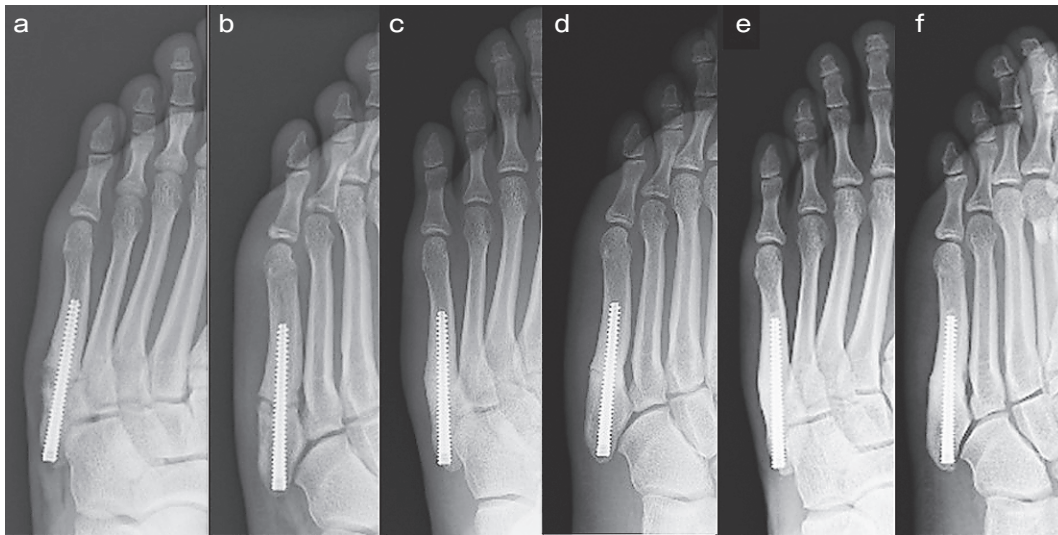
A-P (a) and oblique (b) of foot X-ray, The broken screw was removed 1 month after re-injury, and intramedullary screw re-fixation was performed with an Acutrak 4/5; A-P (c) and oblique (d) foot X-ray images, The patient achieved bone union at 5 months after this re-operation; A-P (e) and oblique (f) foot X-ray images, Two years and 9 months after re-operation.
